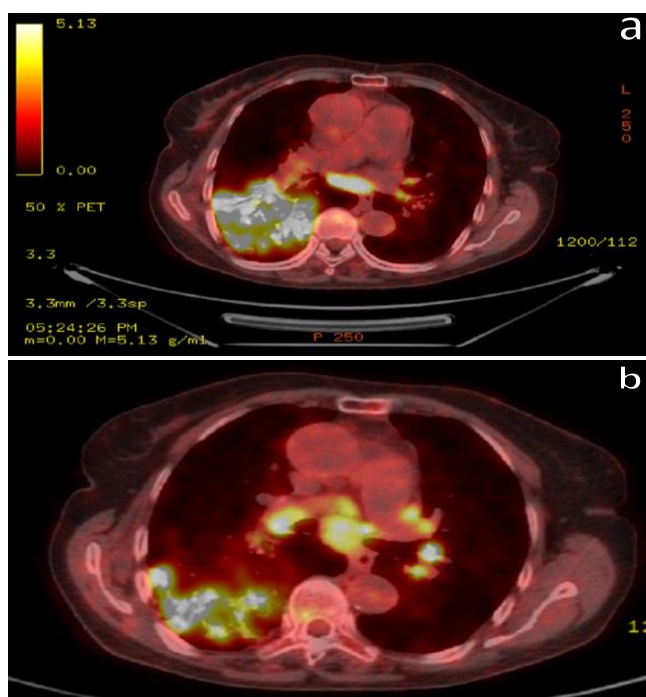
PET-CT revealed an intense FDG accumulation in the consolidation area containing air bronchograms defined in the right lung lower lobe, and hypermetabolic multiple lymph nodes
